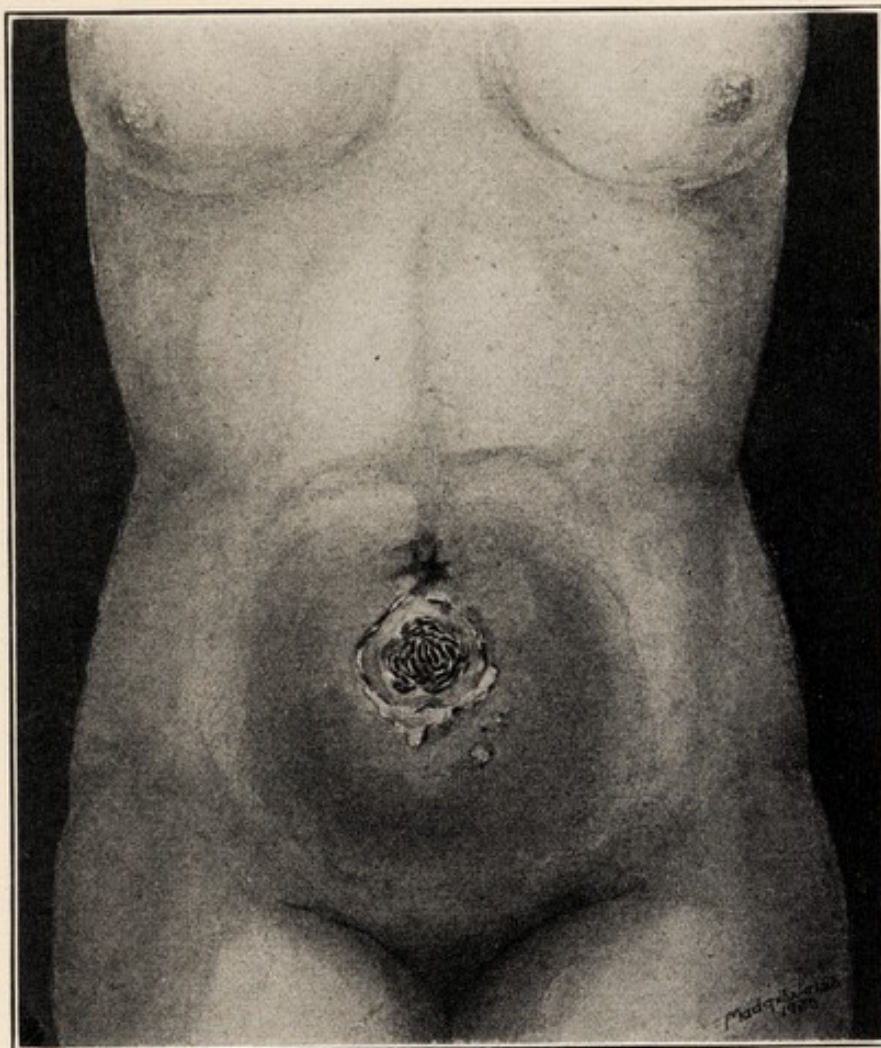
X-RAY ULCER AND INDURATION CAUSED BY THE RE-APPLICATION OF A 130 PER CENT SKIN DOSE WITHIN FOUR MONTHS AFTER THE FIRST APPLICATION. The ulcer appeared three years later.
